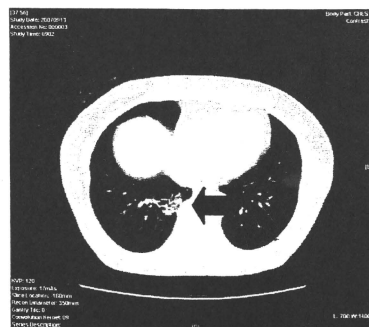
(c) 2007年検診 (HRCT)
